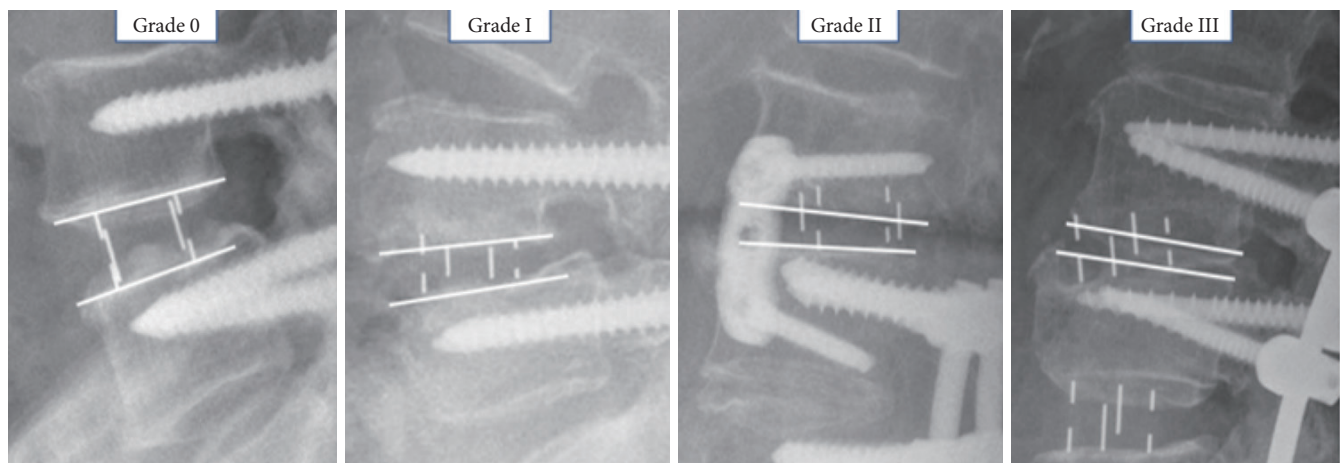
Cage subsidence grading. Lateral plain radiographs showing examples of the different subsidence grades (0–III).
